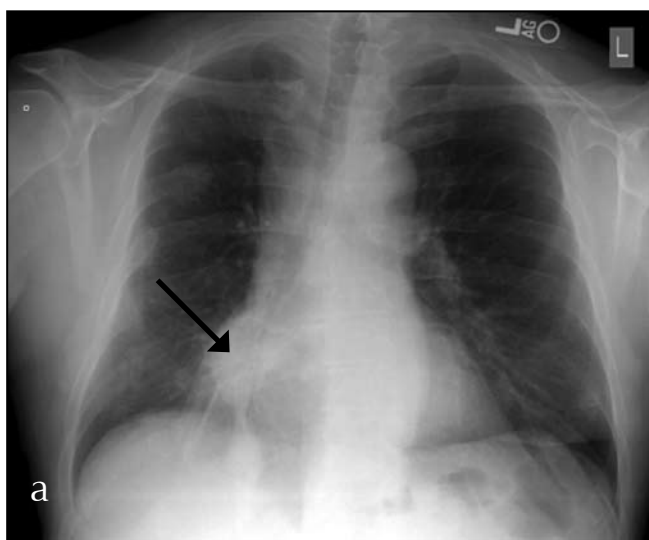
(a) Posterior-anterior chest radiograph shows a large mass (black arrow) in the lower lobe of the right lung. (b) Prone, non-contrast, computed tomogram of the chest at the time of a transthoracic needle biopsy of the right lower lobe mass. Note multiple bilateral nodules of varying shapes and sizes. The dominant right lower lobe mass (white arrow) has air bronchograms within it.
